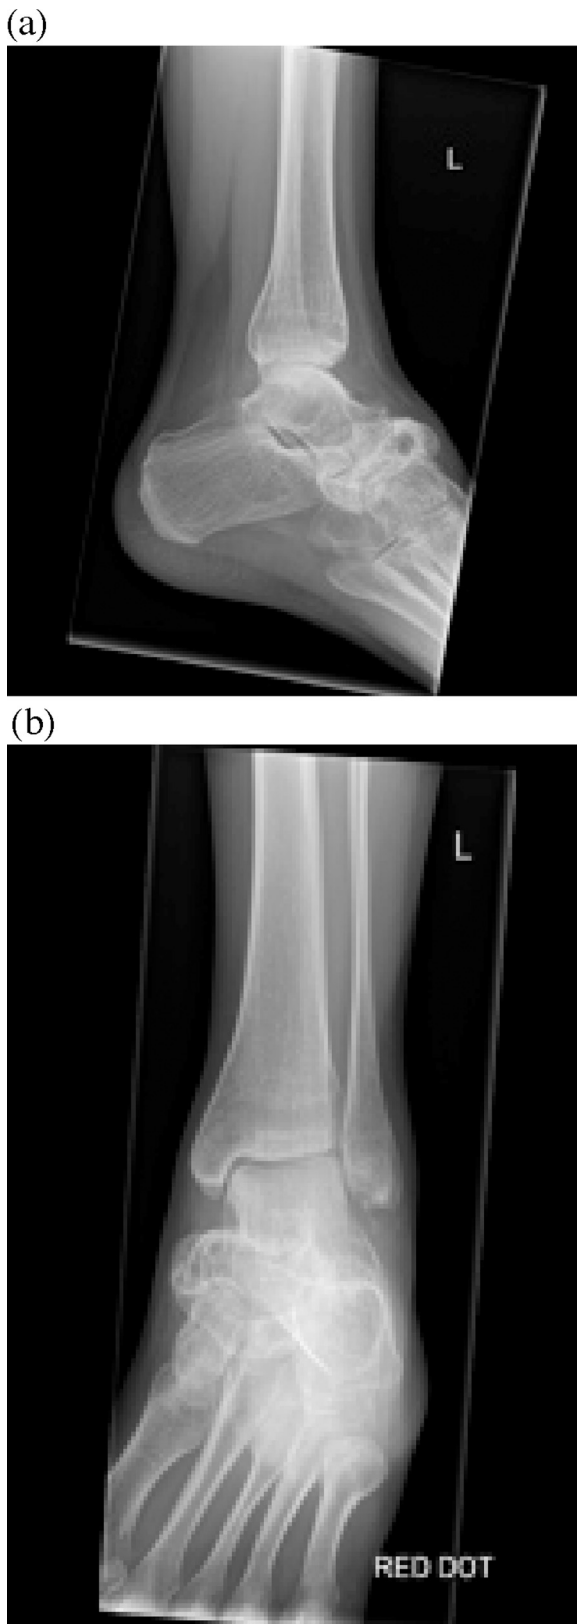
(a) Plain film lateral view. (b) Plain film AP view.
